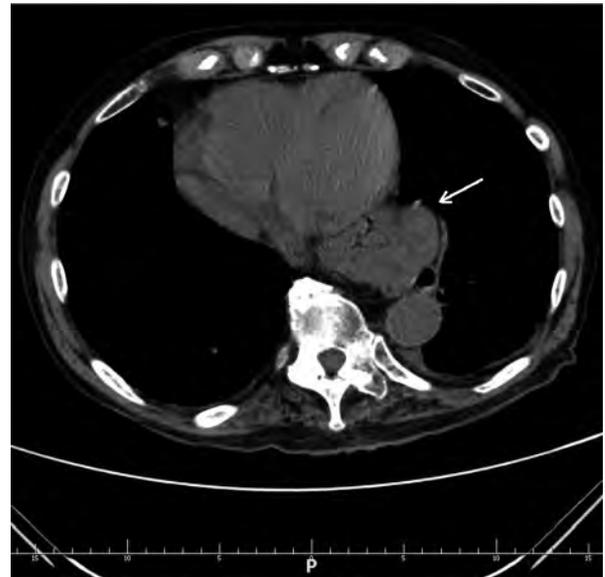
Computed tomography of the chest. A large hiatal hernia imitating a tumour in the mediastinum (arrow)
